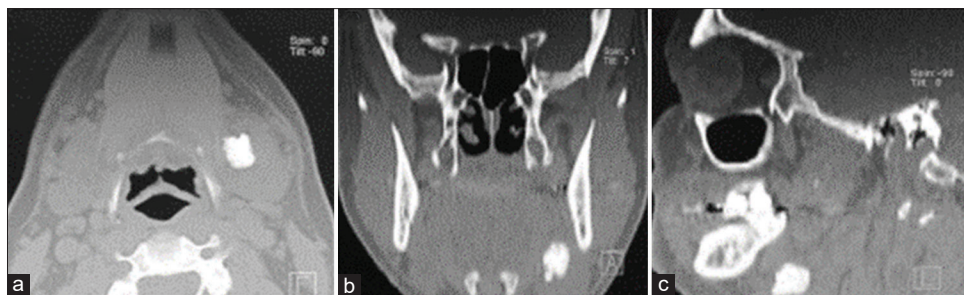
Computed tomography assessment showing hyperattenuating area surrounding the left submandibular gland: (a) Axial section, (b) Coronal section, and (c) Sagittal section
